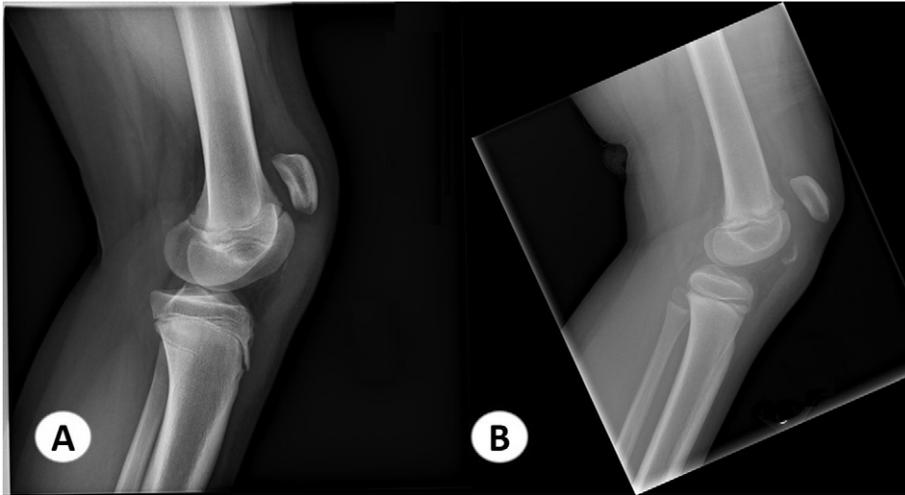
Plain radiographs of the knee in patients with patellar tendon injury. Picture A shows high riding patella with increased Insall–Salvati ratio. Picture B shows detached fragment detected along the line of patellar tendon with high riding patella indicating patellar sleeve fracture.
